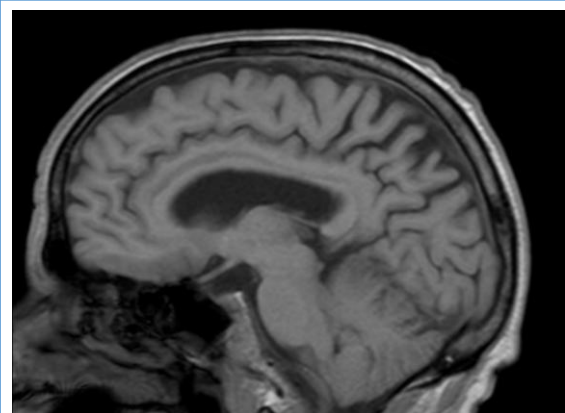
MRI – a) Sagittal cut highlighting a fronto-parietal atrophy b) Coronal cut showing a slight hippocampal atrophy
